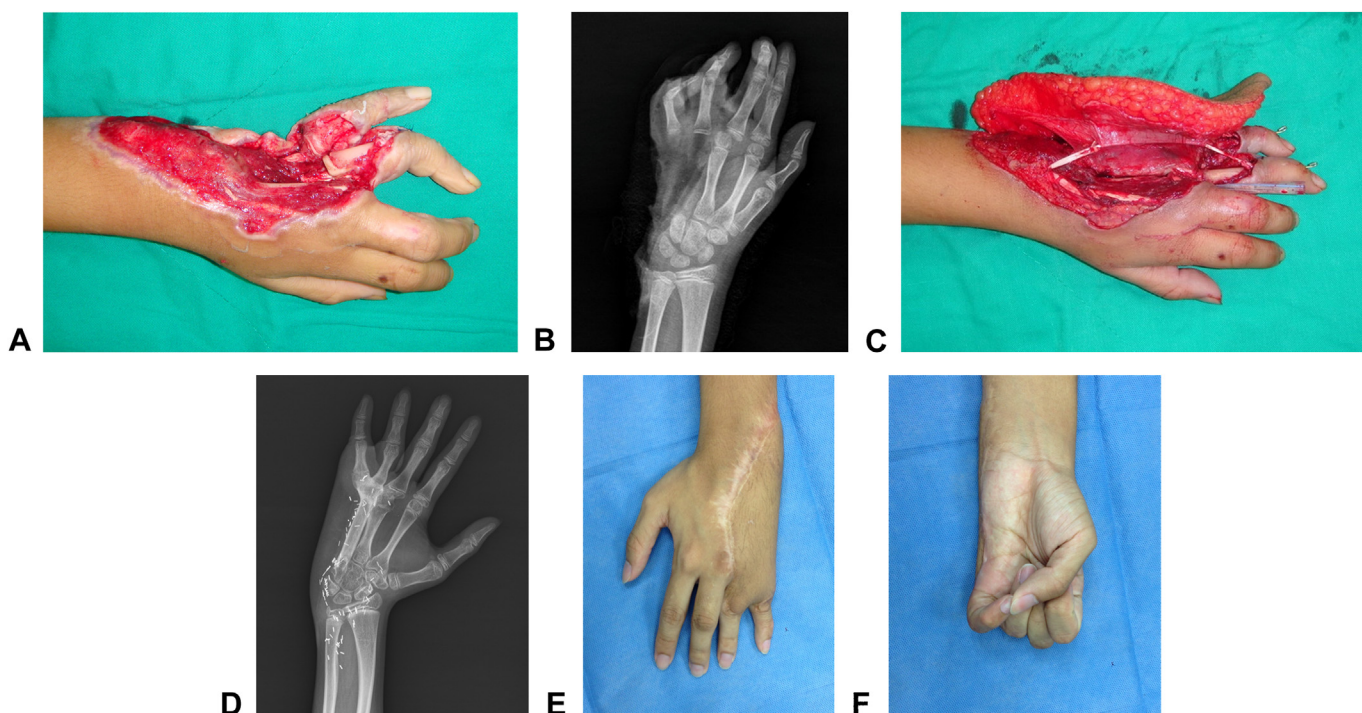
A Left dorsal hand soft tissue defect along with defects in the fourth and fifth metacarpal and extensor tendons. B Preoperative X-ray revealed the fourth and fifth metacarpal defect. C Extensor tendons of the fourth and fifth fingers were reconstructed with plantaris tendon after osteosynthesis. D X-ray at the 2-year follow-up. E, F Acceptable grip function at the 7-year follow-up.
